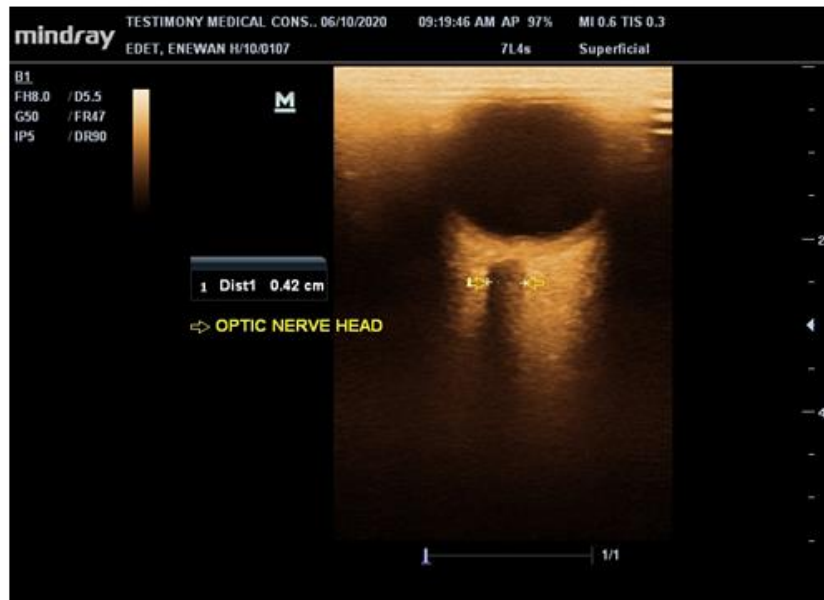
Ultrasound image of the optic nerve sheath diameter
